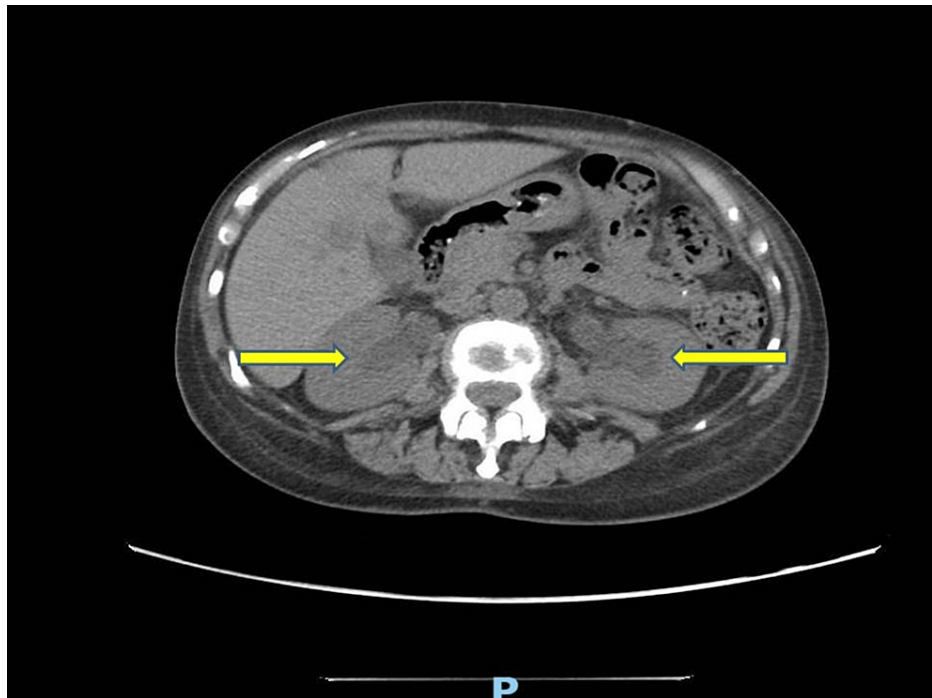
CT abdomen: yellow arrows demonstrating the bilateral hydroureteronephrosis.
